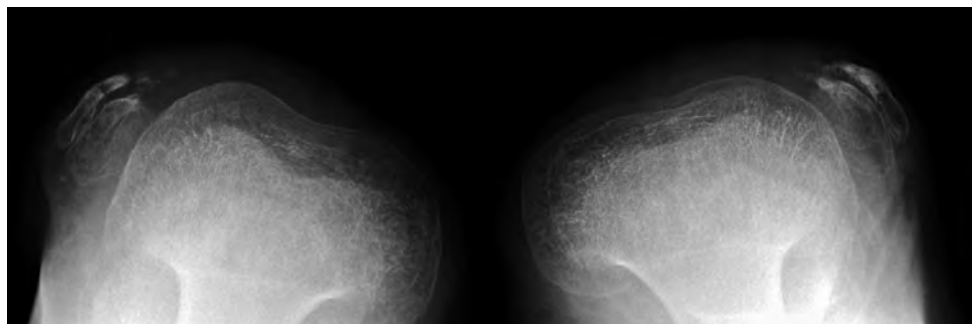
X-ray – axial view of the patellae in a 10-year-old boy with MED. Dislocated two-layered patellae are typical of recessive MED type 4, as demonstrated by genetic testing in this patient.
